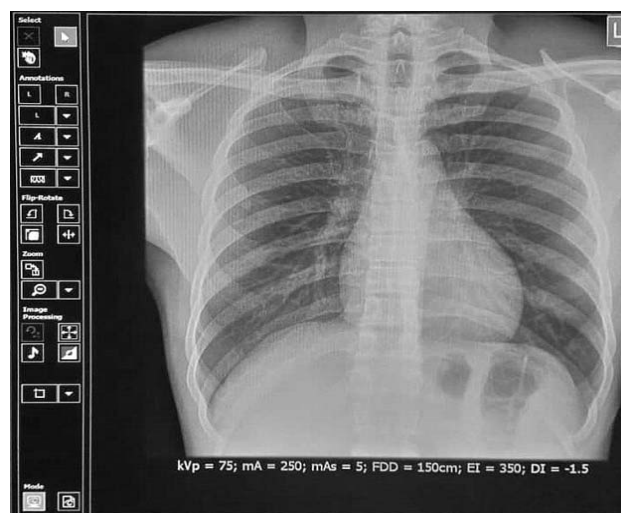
Computed radiography image with negative deviation index have reduced optical density compared to those with positive deviation index
